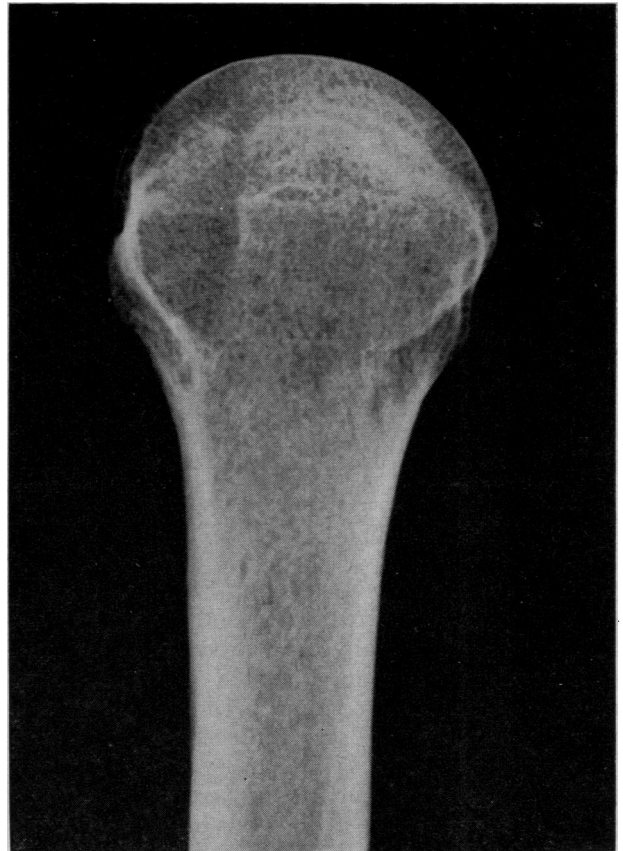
Lateral roentgenogram of upper humerus.
